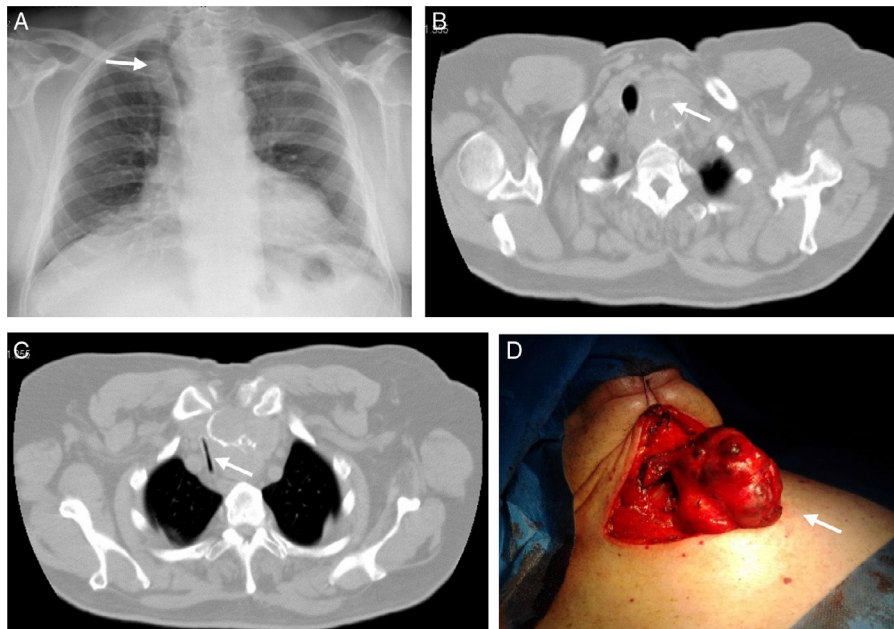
(A) Chest radiograph revealing an enlargement of the superior mediastinum with right deviation of the trachea, (B) Chest computed tomography scan showing a multinodular diving goitre, with compression and critical narrowing of the trachea (C). (D) Total thyroidectomy – resected goitre.
